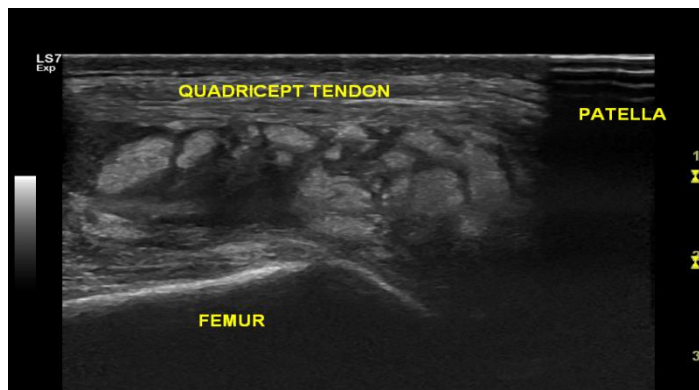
Sample images from the ultrasound scanning during the study showing bony erosions and sub-chondral cysts.
